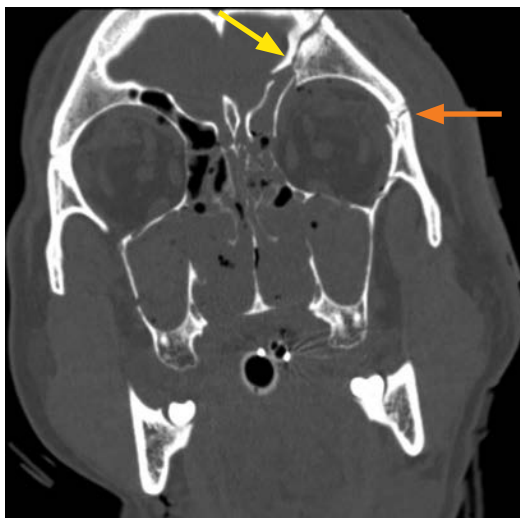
Coronal computed tomographic image of a 24-year-old man after falling from a height of 40 feet. Orange arrow denotes left-sided Le Fort III fracture and yellow arrow denotes left frontal sinus fracture.
